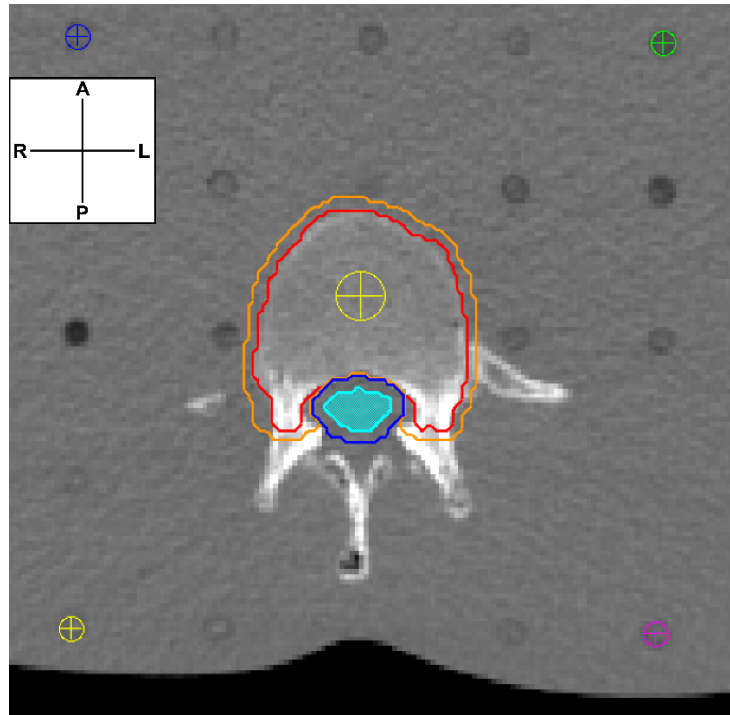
Transverse CT view of the T12 vertebral site in TPS<sub>CS</sub>. The CTV is contoured in red, the PTV in orange, the vertebral foramen in blue, and the spinal cord is shaded in cyan. The yellow point in the vertebral body is the beam isocenter of the plan, and the multicolored points around the site are the TPS registration points. In the coordinate axes, 'A' is the anterior direction, 'P' is posterior, 'R' is patient right, and 'L' is patient left.
